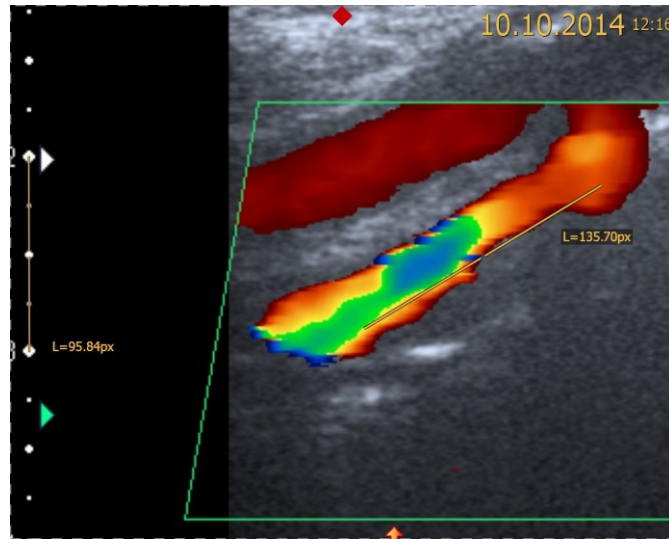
Ultrasound examination (patient 154) showing aICAD of 50% on the right side
